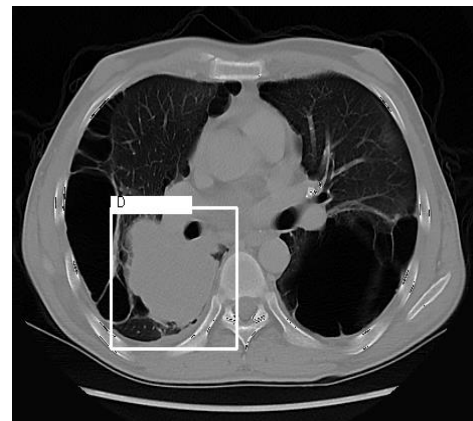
CT scan of a patient with Large Cell Carcinoma. Taken from
